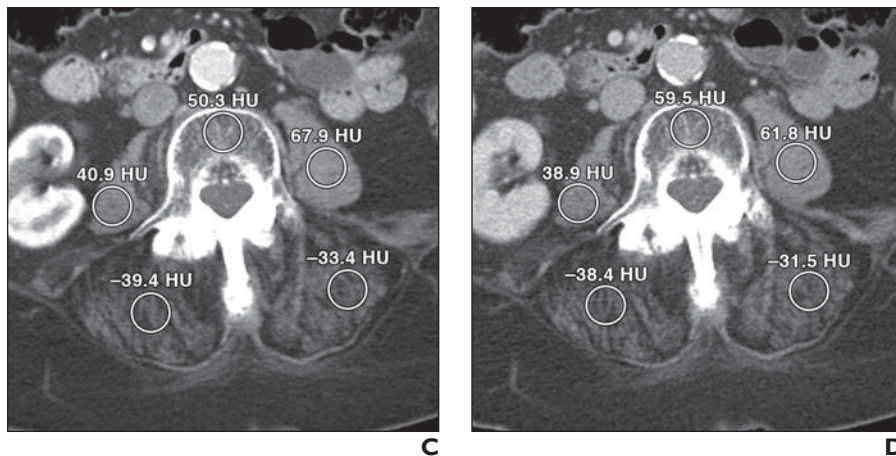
(continued)—88-year-old woman with right upper quadrant and back pain. (Reprinted from [20]) A–D, Representative four-phase CT scans obtained in unenhanced phase (A), arterial phase (B), portal phase (C), and delayed phase (D) show ROIs (circles) for psoas muscles, posterior paraspinal muscles, and L4 vertebral body. For example, attenuation of L4 vertebral body increased from 32.9 HU in unenhanced phase to 40.6 HU in arterial phase, 50.3 HU in portal phase, and 59.5 HU in delayed phase. Attenuation of abdominal aorta also was measured on each of four phases of CT examination at L3 level above level of aortic bifurcation (not shown). In A, dotted lines show freehand ROIs drawn on unenhanced images outlining both psoas muscles.
